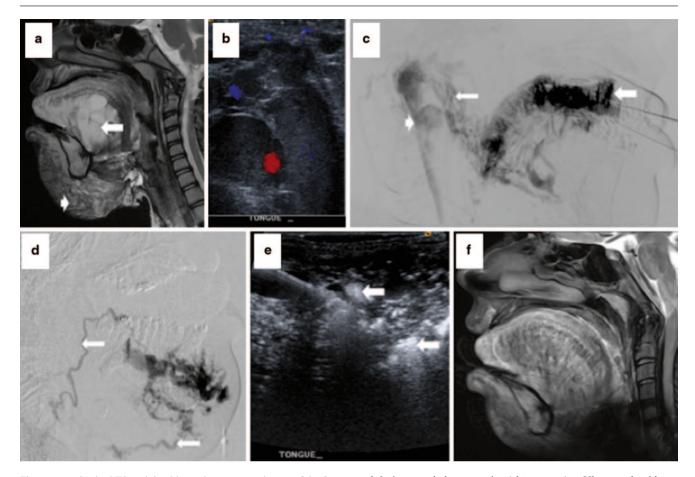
a Sagittal T2-weighted inversion recovery image of the face in a 14-year-old boy demonstrating significant macrocystic disease in the tongue (*long arrow*) and combined disease in the cervico facial area (*short arrow*). b Color duplex demonstrating large cysts with echogenic lymph within the cysts. Few vessels are seen coursing through the cystic mass. c Digital subtraction contrast study demonstrating filling of the macrocysts which drain into the internal jugular veins (*short arrow*)
